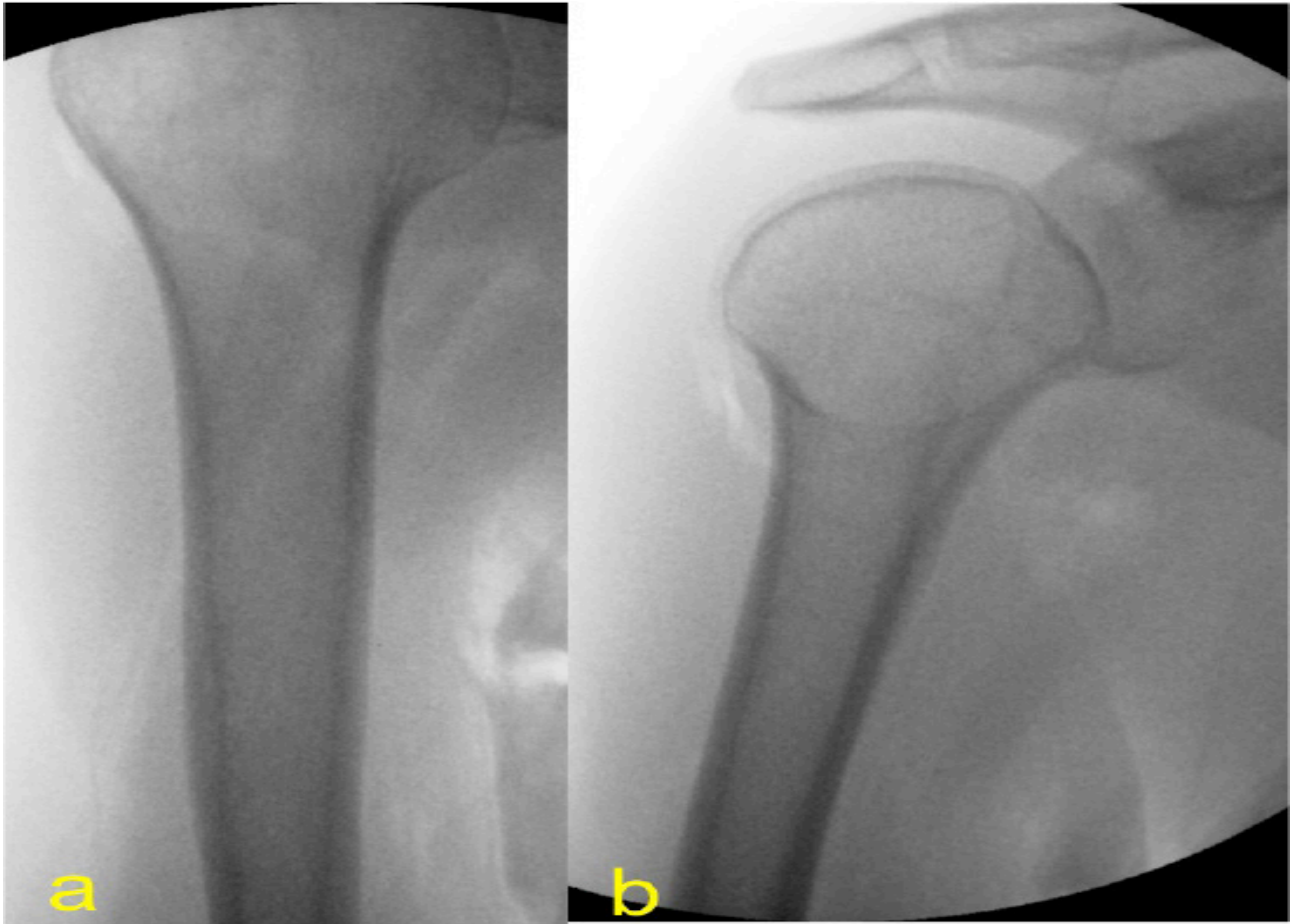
Intra-operative antero-posterior(a) and lateral(b) radiographs of the proximal humerus, revealing the absence of calcific deposit.
